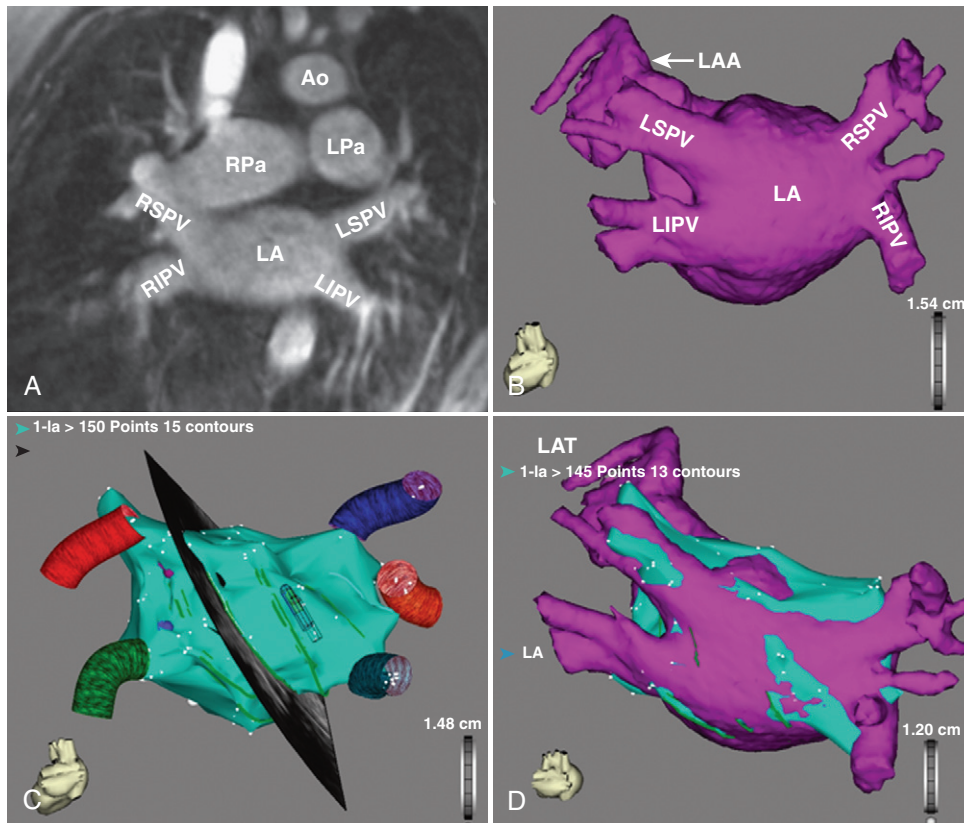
Image integration into clinical mapping system. A, Magnetic resonance angiography demonstrating anatomy of left atrium (LA) and pulmonary vein (PV). B, Three dimensional reconstructed anatomic shell (MRI/CT) demonstrating the PV ostia and branching patterns. C, Electroanatomic map using CartoSound. Two-dimensional ultrasound (shown in black section) used for reconstruction of LA. White points in the turquoise shell signify endocardial catheter positions used for validation of ultrasound-based reconstruction. Colored tubes symbolize PVs. D, Successful registration of electroanatomic map (turquoise shell) with the three-dimensional LA reconstruction (purple shell) demonstrating good merging of LA body and PV anatomy. *Ao*, Aorta; *CT*, computed tomography; *LA*, left atrium; *LAA*, left atrial appendage; *LAT*, lateral; *LIPV*, left inferior pulmonary vein; *LPA*, left pulmonary artery; *LSPV*, left superior pulmonary vein; *MRI*, magnetic resonance imaging; *PV*, pulmonary vein; *RIPV*, right inferior pulmonary vein; *RPa*, right pulmonary artery; *RSPV*, right superior pulmonary vein. (A, Courtesy Dr. Jean Jedy.)
